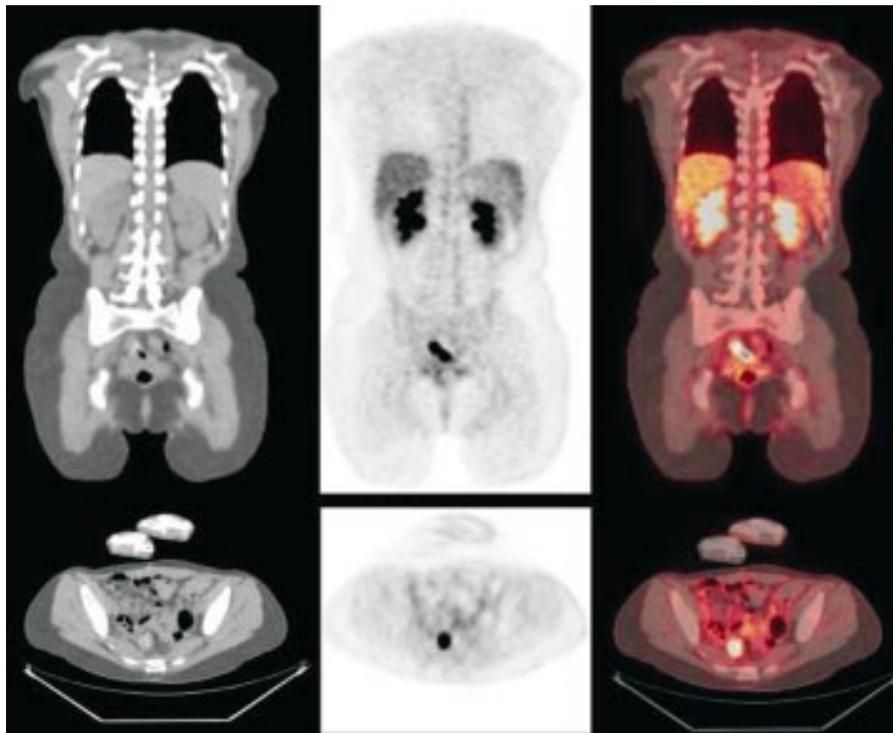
A 45 year old woman with stage III colorectal cancer presented with rising CEA after primary tumour resection. (Top row) Coronal and (bottom row) transaxial tomographic slices. (Left) CT was interpreted as negative for recurrence. (Centre) FDG PET shows intense activity at the anastomosis compatible with tumour recurrence. This was subsequently verified after surgery. (Right) Fusion of PET and CT localises the abnormality.
